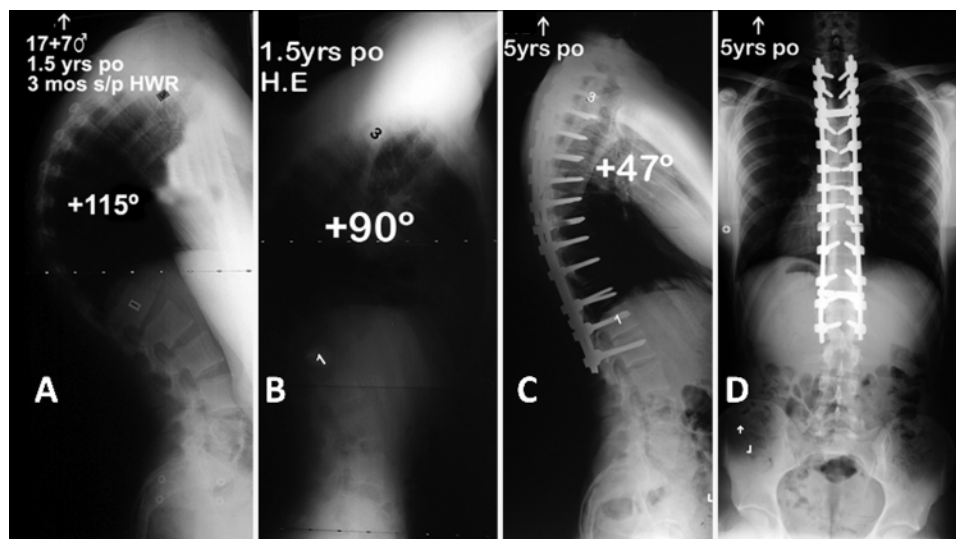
Case 1. Preoperative standing lateral (A), preoperative supine hyperextension lateral (B), postoperative standing lateral (C), and postoperative standing anteroposterior (D) 36-inch radiographs. H.E = hyperextension; HWR = hardware removal; po = postoperative; s/p = after.
